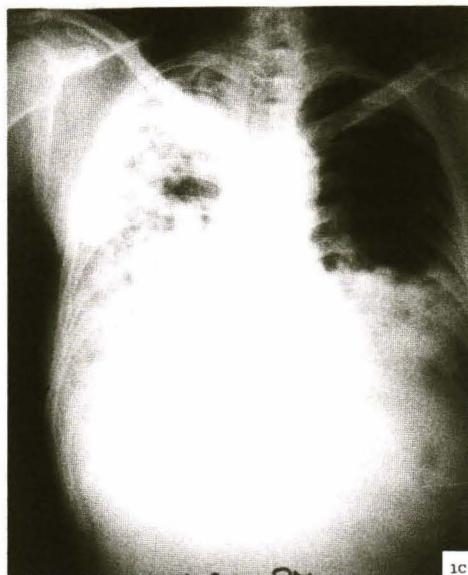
Eight months after treatment with mebendazole, despite clinical improvement, the chest radiograph revealed slightly increased infiltration in the right lung.
